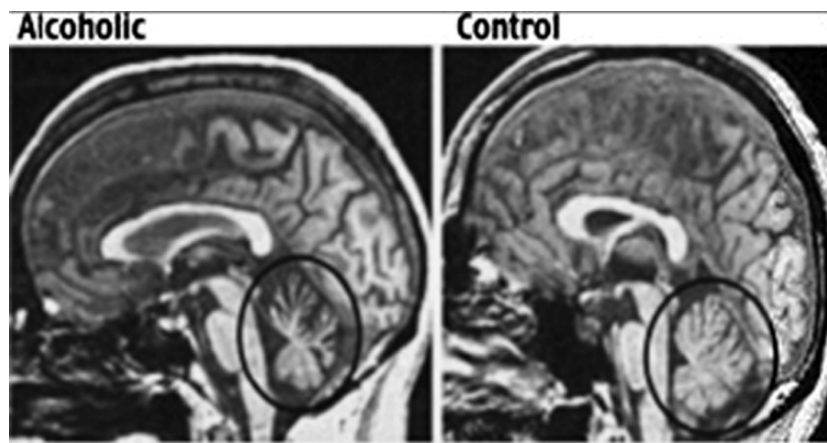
Midsagittal view of a magnetic resonance imaging (MRI) scan of the brain of an alcoholic person, showing severely shrunken folia of the anterior superior vermis compared with an age-matched control man (taken from reference (16); Fig. 2, p. 588; with kind permission of Springer Science and Business Media).
